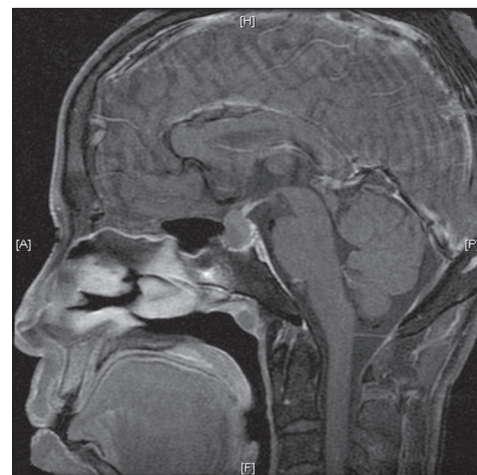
Magnetic resonance imaging pictures well-defined sellar-suprasellar heterogenous lesion and mildly hyperintense on T1-weighted (T1W) images and brightly hyperintense on T2-weighted (T2W) images suggestive of Rathke's cyst
